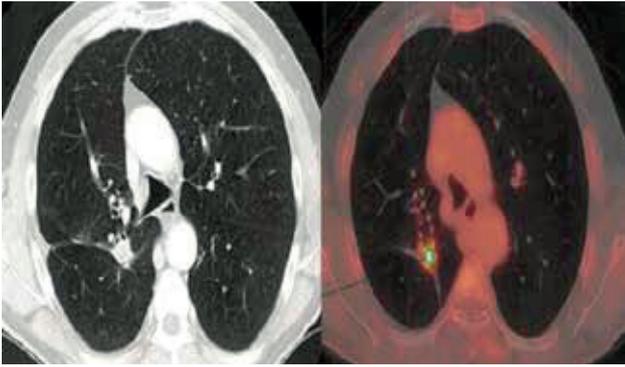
CT and PET CT that shows the appearance of a metabolically active suspicious node in the RSL contiguous to the surgical suture attributable to the local relapse.
